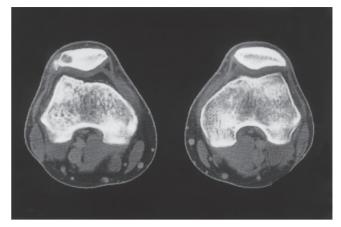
Computed tomography (CT) revealed a cystic lesion in the right patella, with a sclerotic rim, and irregular highdensity spotty areas in the surrounding soft tissue
